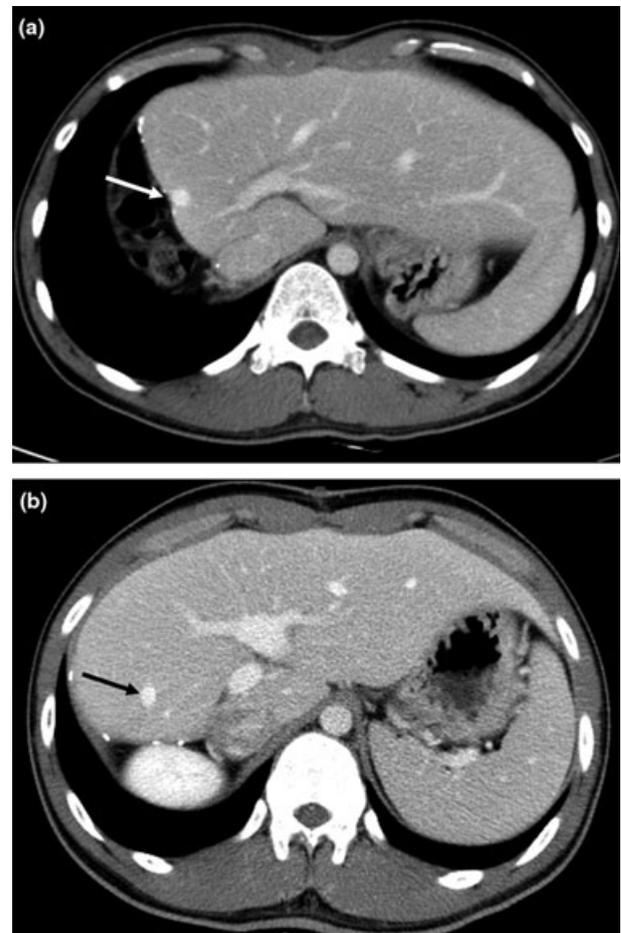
Postoperative CT scans taken 6 months after right hepatectomy. (a) In the cRL donor, the middle hepatic vein (MHV) is located on the resection margin (white arrow). (b) In the mRL donor, the MHV is deeply located in the segment IV (black arrow).
